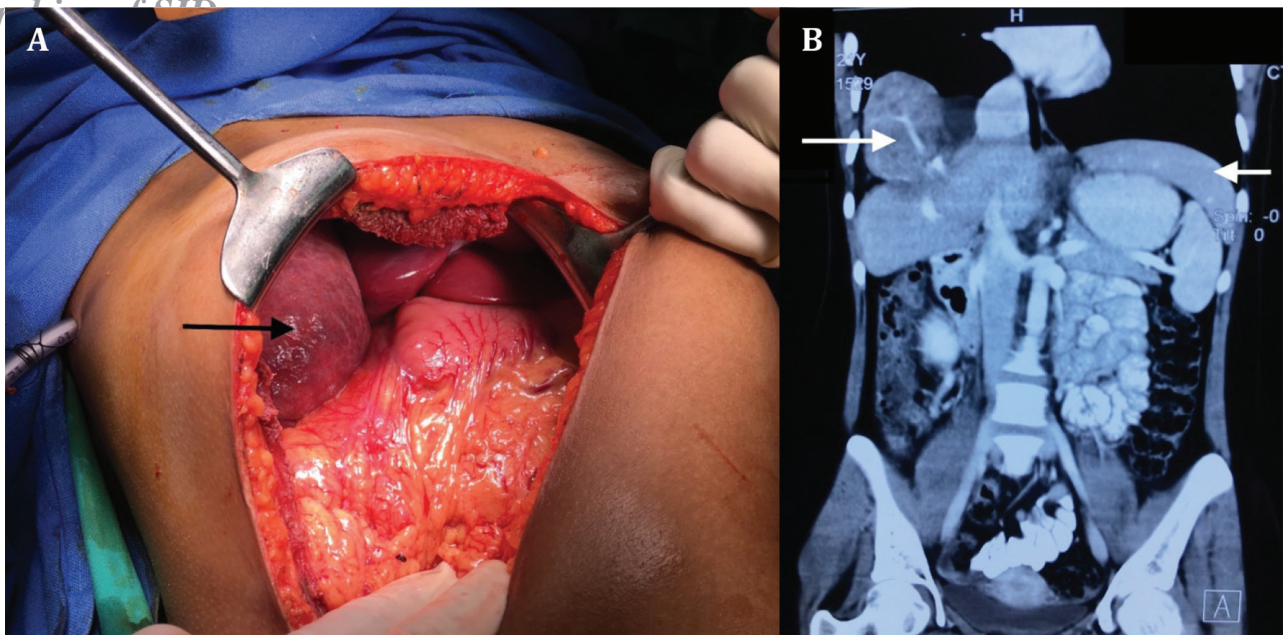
Ruptured right lobe that had herniated through diaphragmatic defect (arrow) (A); Coronal abdominopelvic computed tomography (CT) image with intravenous contrast injection showing fractured right lobe of liver herniating into the right pleural cavity (arrow on right); enlarged left lobe draping around spleen (arrow on left) (B).
